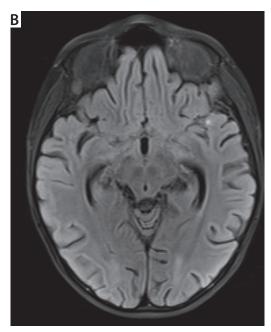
Head MRI – FLAIR sequence, transverse cut; (A) hyperintense foci in the basal ganglia – in claustrum on the right side, in the globus pallidus on the left side. Image suggestive of early ischaemia of basal ganglia. Regression of lesion (B)
